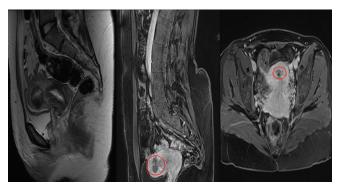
Enhanced pelvic magnetic resonance imaging after 7 and 18 months of uterine artery embolization showing complete avascular atrophy of endometrial polyps
